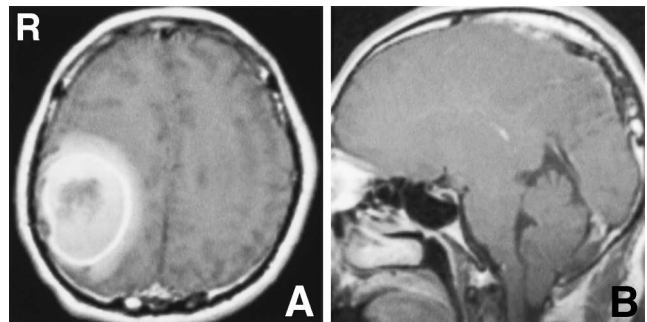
A: Preoperative T₁-weighted magnetic resonance image with contrast medium showing a massive hematoma in the right parietal lobe, without enhancement. B: Sagittal T₁-weighted magnetic resonance image showing downward herniation of the tonsils.
